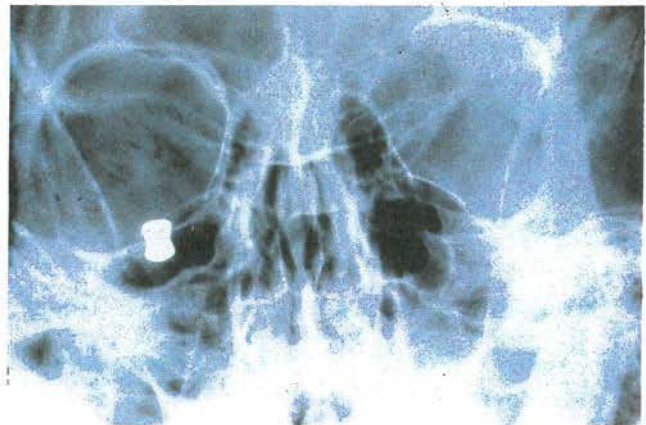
Plain radiograph showing a right airgun pellet
